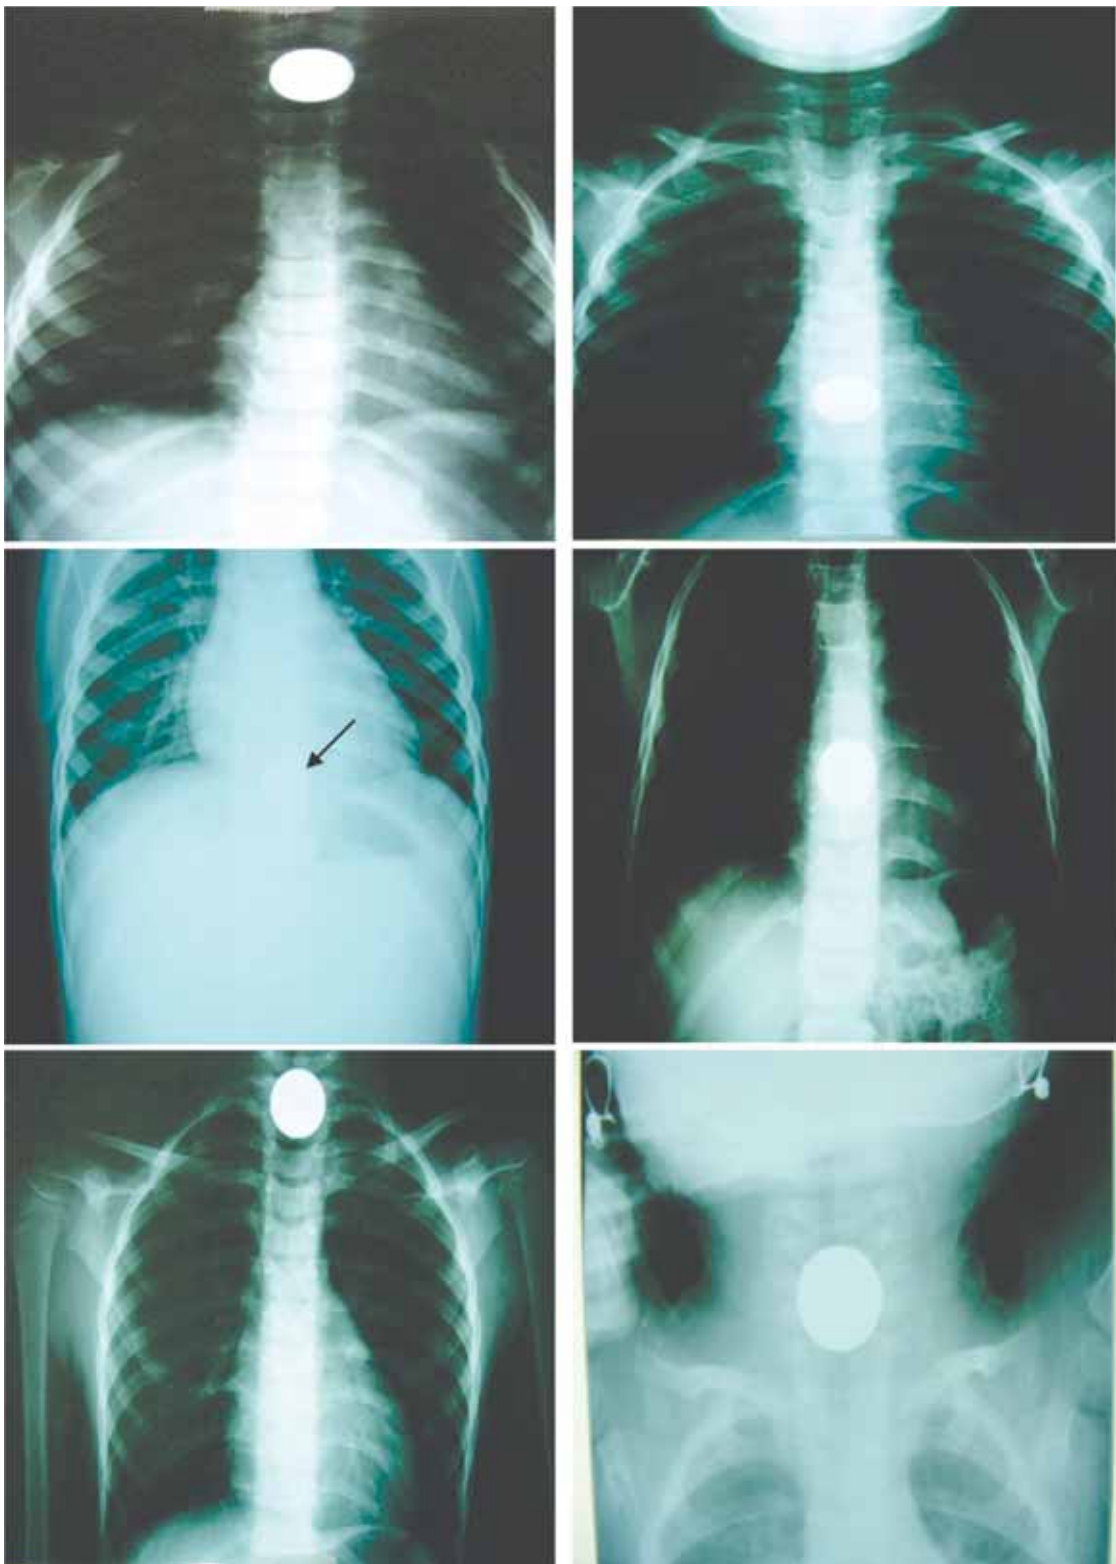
Coins in the esophagus – X-ray examination
